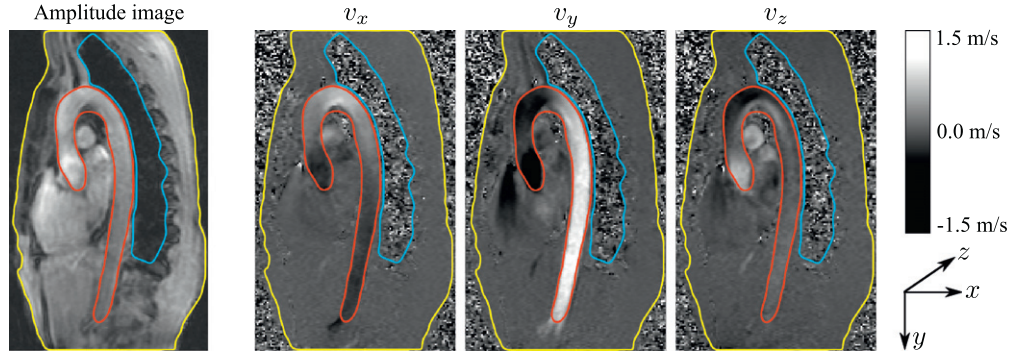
One 2D slice of a Phase-Contrast MRI data set. The leftmost image shows the magnitude image $I(\mathbf{x})$, cf. Eq. (3). The three rightmost images show the flow velocities in the x , y , and z directions, estimated as described in Section 2.2. The body of the patient has been outlined in yellow, the aorta in red and the lung in blue. High flow can be seen in the aorta region. The probability distribution of the velocity components due to Gaussian image noise is shown to be Gaussian in the high-SNR areas. In the low-SNR areas outside the body and in the lung, the intensity distribution is different, which is clearly seen in the velocity images. (For interpretation of the references to colour in this figure legend, the reader is referred to the web version of this article.)
